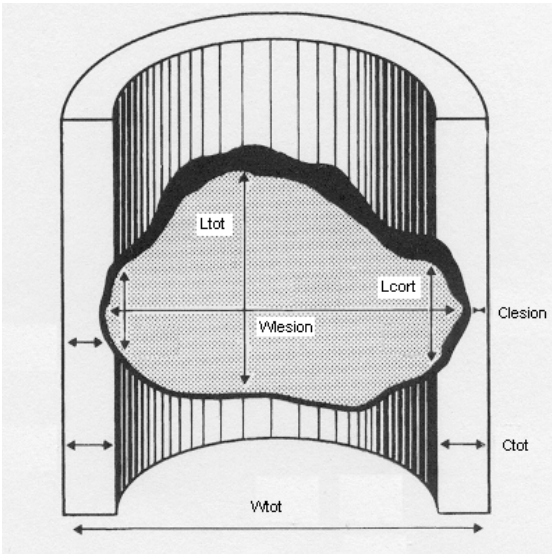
Measurement of metastatic lesions in the femur (in mm): largest axial measurement of lesion (L-lesion), largest transverse extension of the lesion (W-lesion), largest axial cortical involvement (L-cort). (Reprinted with permission from: van der Linden YM, Kroon HM, Dijkstra SPDS, Lok JJ, Noordijk EM, Leer JWH, et al. Simple radiographic parameter predicts fracturing in metastatic femoral bone lesions: results from a randomised trial. Radiotherapy and Oncology. 2003; 69(1):21-31)
